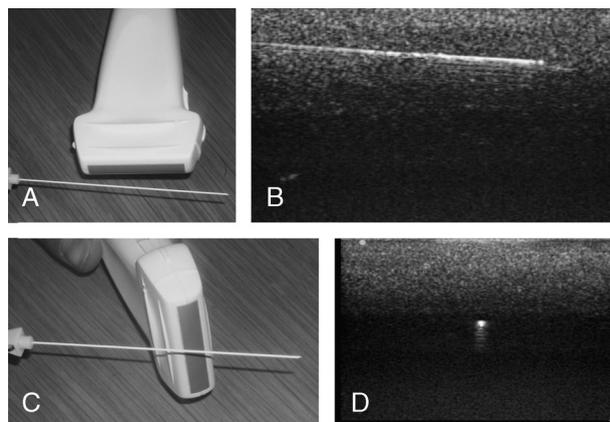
Ultrasound terminology for describing needle insertion techniques. A and B represent the in-plane approach to needle insertion. In this approach, a long-axis view of the needle is being generated. C and D represent the out-of-plane approach to needle insertion. In this approach, a short-axis view of the needle is generated.
